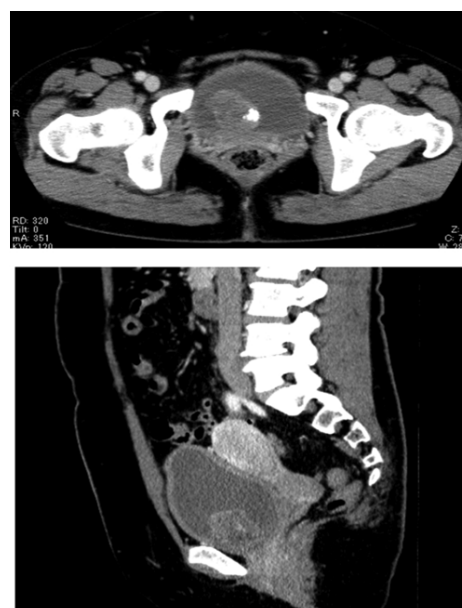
CT scan showing heterogeneously enhanced 4 cm mass involving the bladder neck and anterior wall. No enlarged lymph node was detected [20]
